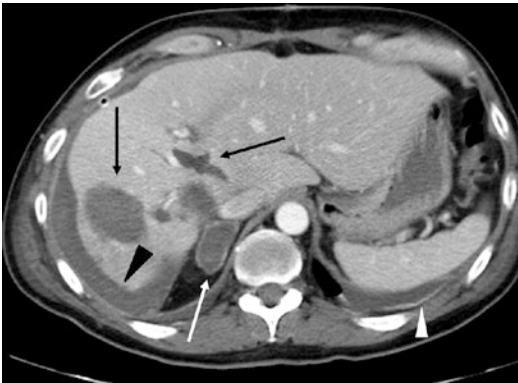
Motorbike accident. Adrenal hematoma: enhanced CT shows hypodense enlarged adrenal gland, the adrenal capsule is expanded and enhanced (white arrow). Note the associated lesions in hepatic right parenchyma (black arrows), and the presence of perihepatic hemoperitoneum (black arrowhead) and a small amount of free right pleural free fluid (white arrowhead)
